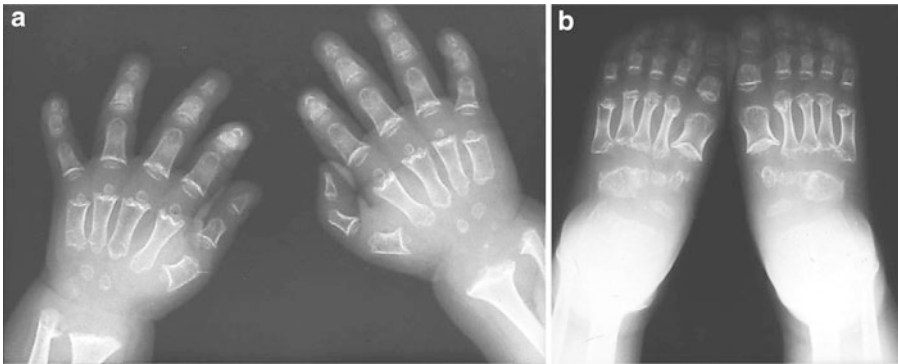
(a, b) Radiographs of the hands (a) and feet (b) show grossly disturbed metaphyseal and epiphyseal ossification, short and stubby tubular bones, somewhat widened metacarpals and metatarsals, and small and markedly irregular carpal and tarsal bones
